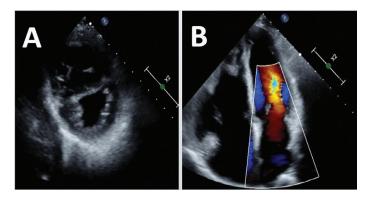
Baseline echocardiogram transthoracic. A, Abnormal septal motion. B, Moderately dilated left and right atria. Severely enlarged right ventricle with evidence of right ventricular pressure and volume overload.
